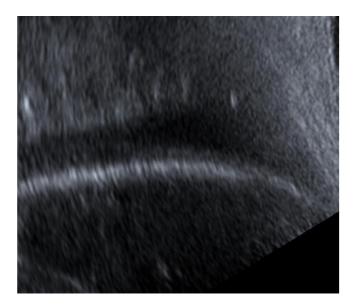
Small pleural effusion right (evaded thorax x-ray); high FS right in sitting position
